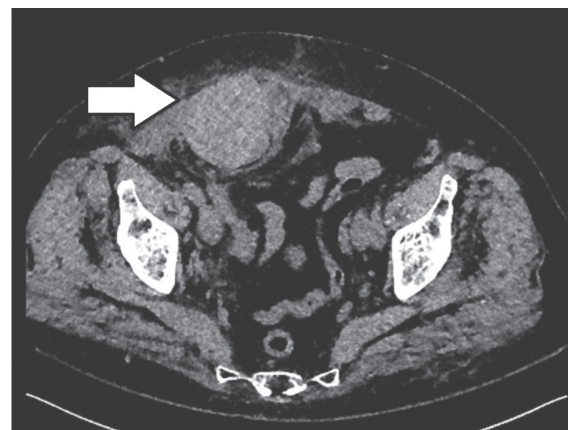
Abdominal computed tomography without contrast enhancement in a 62-year-old patient taking warfarin who presented with acute pain and swelling of the anterior abdominal wall. There is a hematoma — hyperdense (+73HU) homogeneous well-circumscribed round mass in the anterior abdominal wall (data obtained by the authors of the article)
